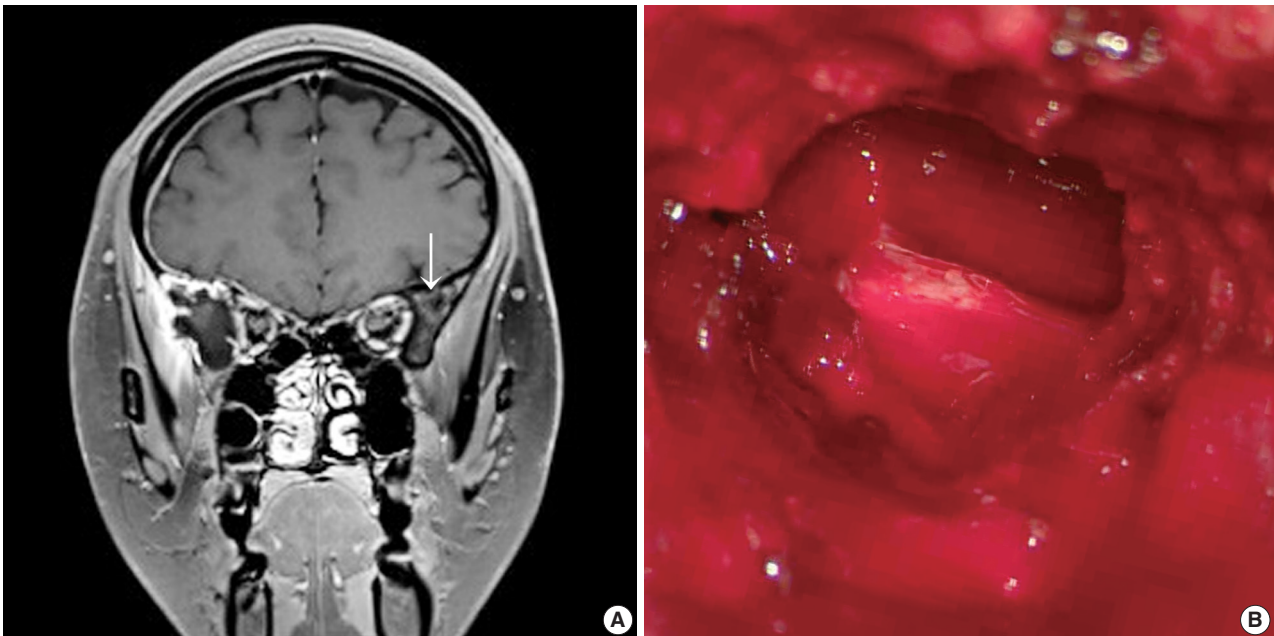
(A) Brain magnetic resonance image shows a slightly enhanced lesion (arrow) at the right sphenoid bone. (B) Intraoperative gross examination of the lesion shows cystic spaces filled with blood and solid texture.
